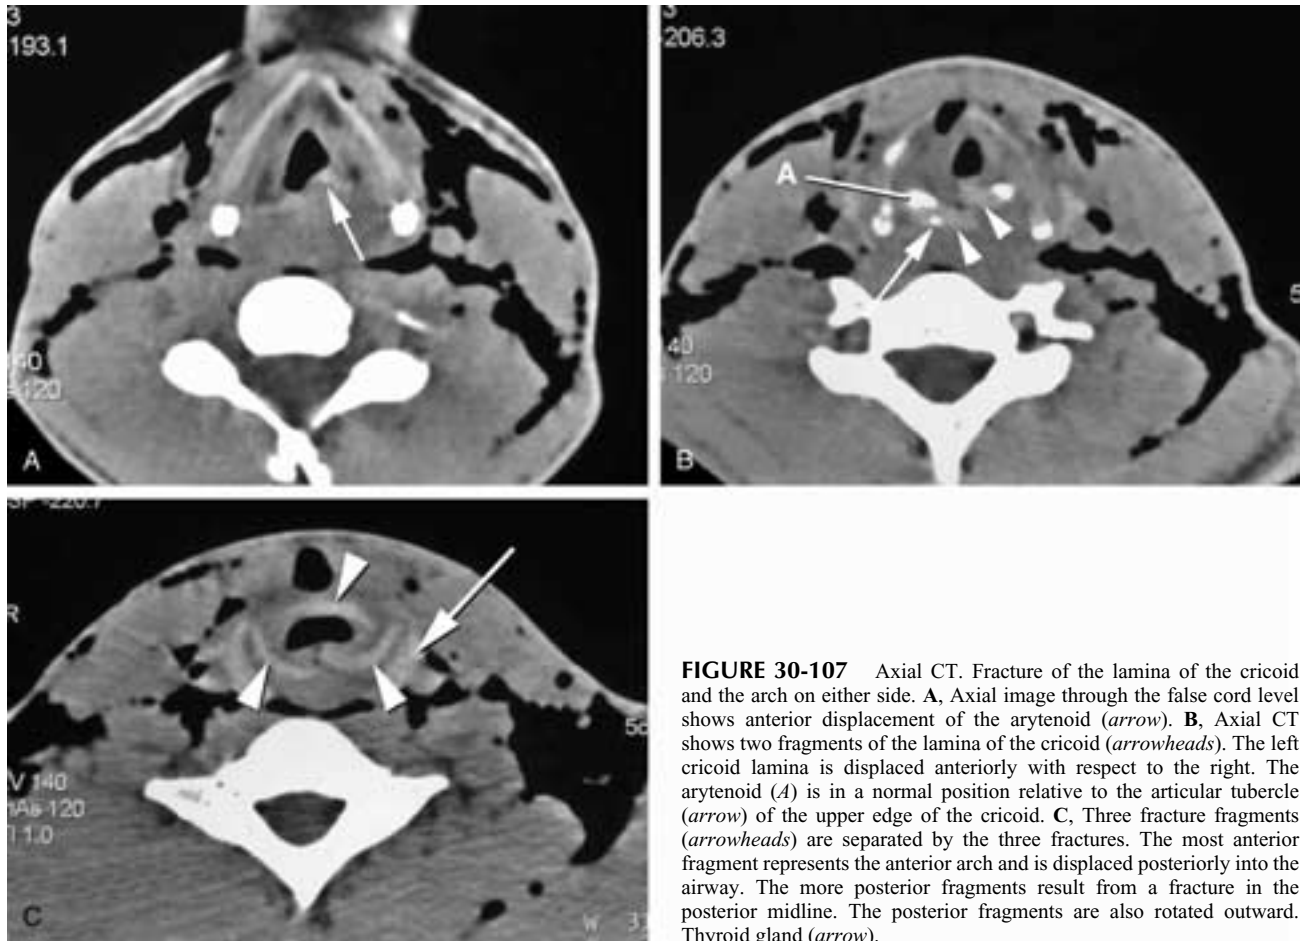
Axial CT. Fracture of the lamina of the cricoid and the arch on either side. A, Axial image through the false cord level shows anterior displacement of the arytenoid (arrow). B, Axial CT shows two fragments of the lamina of the cricoid (arrowheads). The left cricoid lamina is displaced anteriorly with respect to the right. The arytenoid (A) is in a normal position relative to the articular tubercle (arrow) of the upper edge of the cricoid. C, Three fracture fragments (arrowheads) are separated by three fractures. The most anterior fragment represents the anterior arch and is displaced posteriorly into the airway. The more posterior fragments result from a fracture in the posterior midline. The posterior fragments are also rotated outward. Thyroid gland (arrow).
